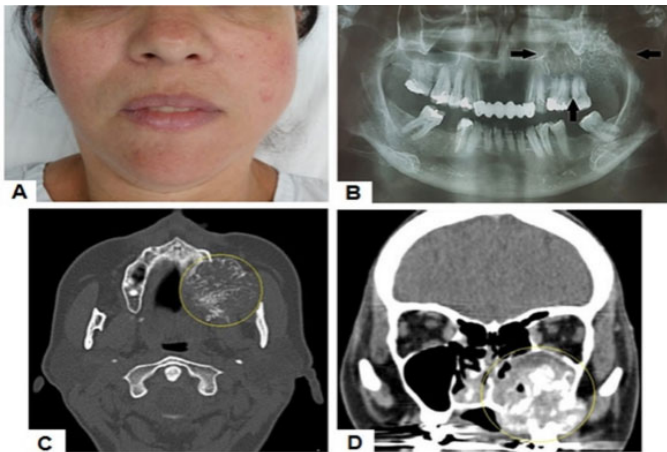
Clinical and radiological characteristics of the tumor. (A) Extraoral clinical appearance showing asymmetry of the middle third of the face. (B) Orthopantomography showing mixed unilocular lesion in the left maxilla (black arrows). Computed tomography of the lesion in the axial (C) and coronal (D) planes showing the extension of the neoplasm (yellow circles).
